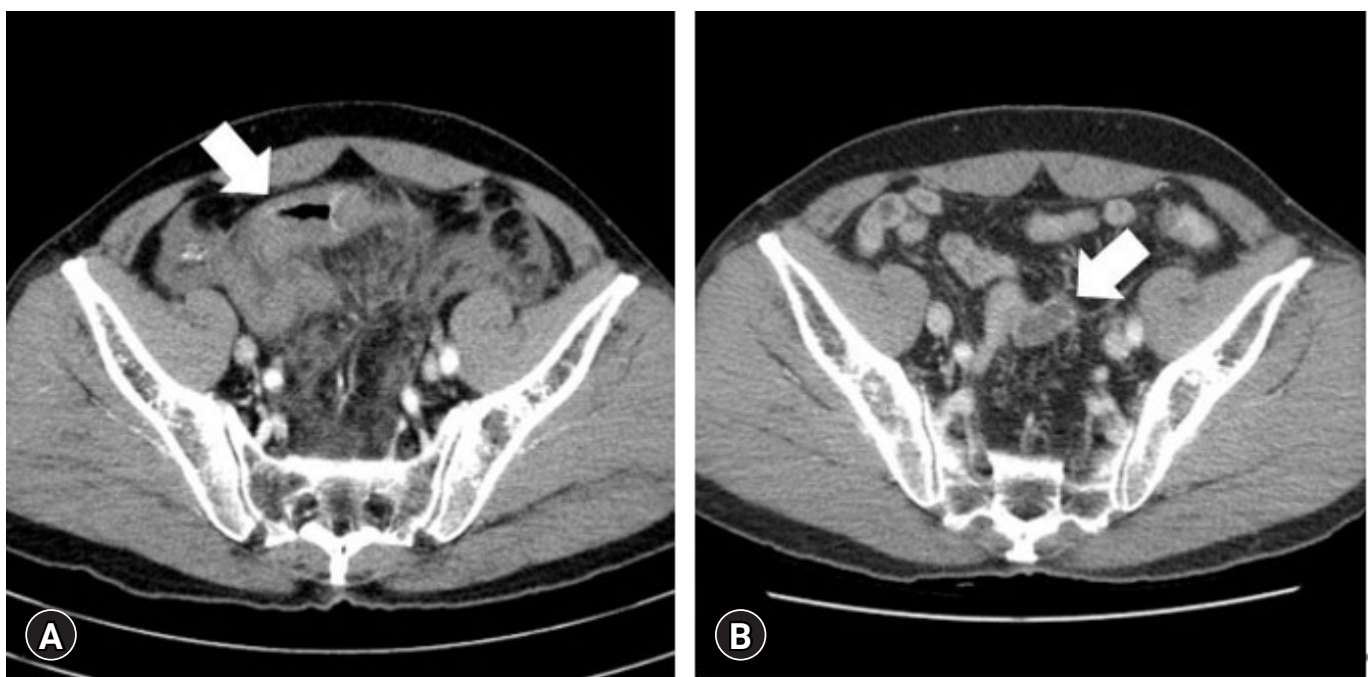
Computed tomography scan performed (A) 4 hours and (B) 7 weeks posttrauma. (A) Ischemia and diffuse wall thickening in the sigmoid colon (arrow) and hematoma in the mesocolon with a circumference of 11 cm. (B) A 2.7-cm hematoma in the sigmoid mesocolon (arrow).
